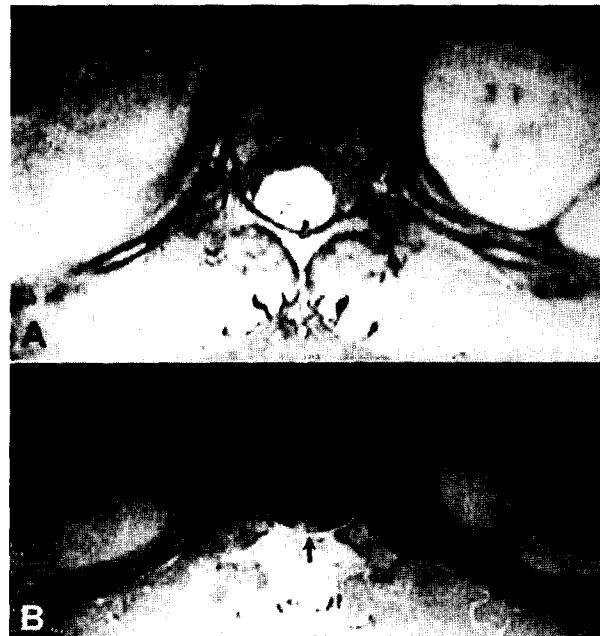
Gadolinium-enhanced axial MR images of the spinal cord at T1. (A) Preoperative MRI shows an enhanced tumor mass occupies the dorsal part of the cord (large arrow). (B) The tumor was totally removed with a small part of cord tissue left (between 2 small arrows).
